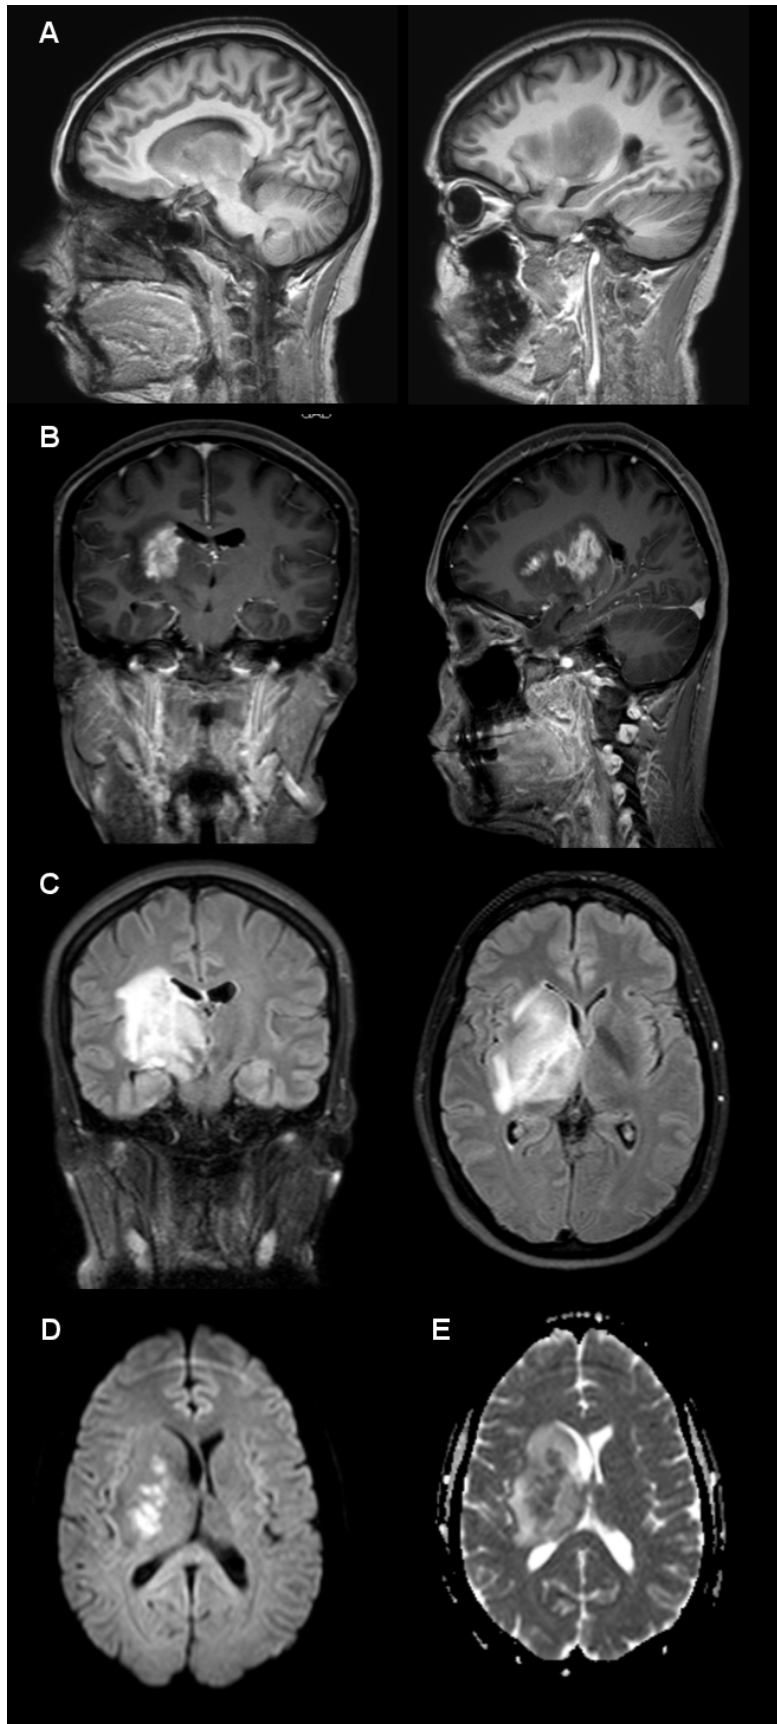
Cranial MRI. A: before gadolinium. B: after gadolinium: central enhancement is evident. C: FLAIR: periventricular high-signal intensity lesion (coronal and sagittal sections). D: Diffusion Weighted (DW): hydric restriction at the center of the lesion. E: Apparent Diffusion Coefficient (ADC): weaker signal.
